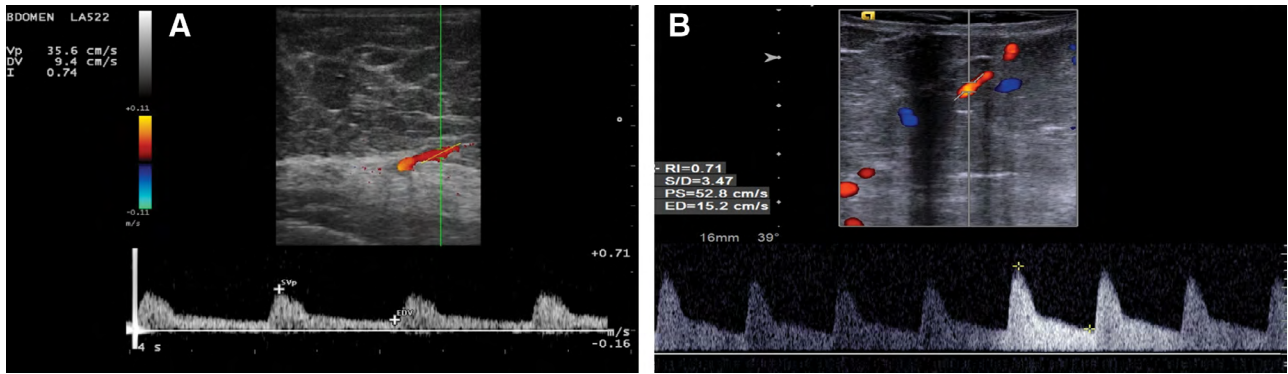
Doppler US confirms increased flow following vascular delay. A, Preoperative Doppler US of “nonideal” CTA-based DIEP (decreased amplitude). B, Increased blood flow (increased amplitude) through delayed DIEP. US, ultrasound.
